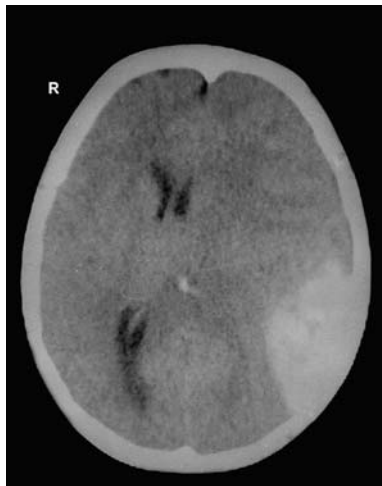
Case no 2: CT-scan after 15 days. Picture of large left-sided epidural haematoma
